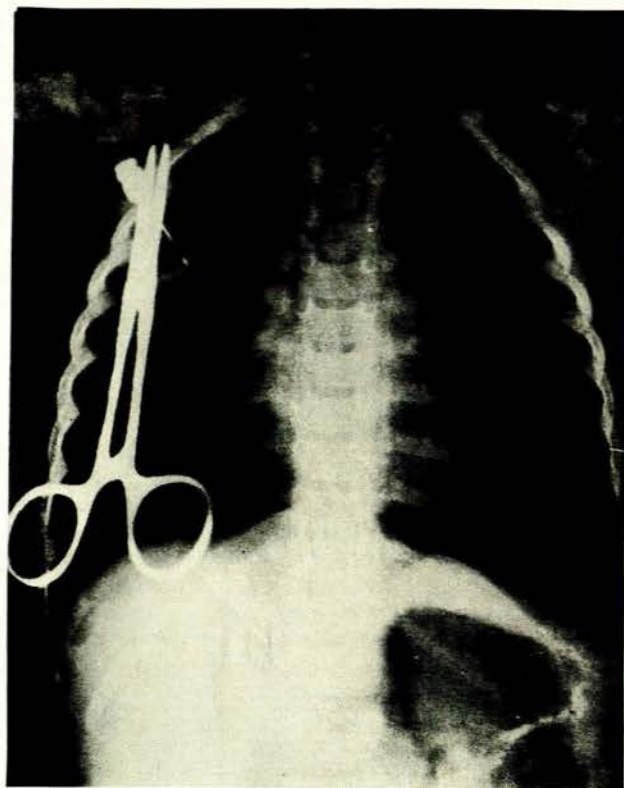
Chest X-ray of case 1, showing severe pneumothorax.
